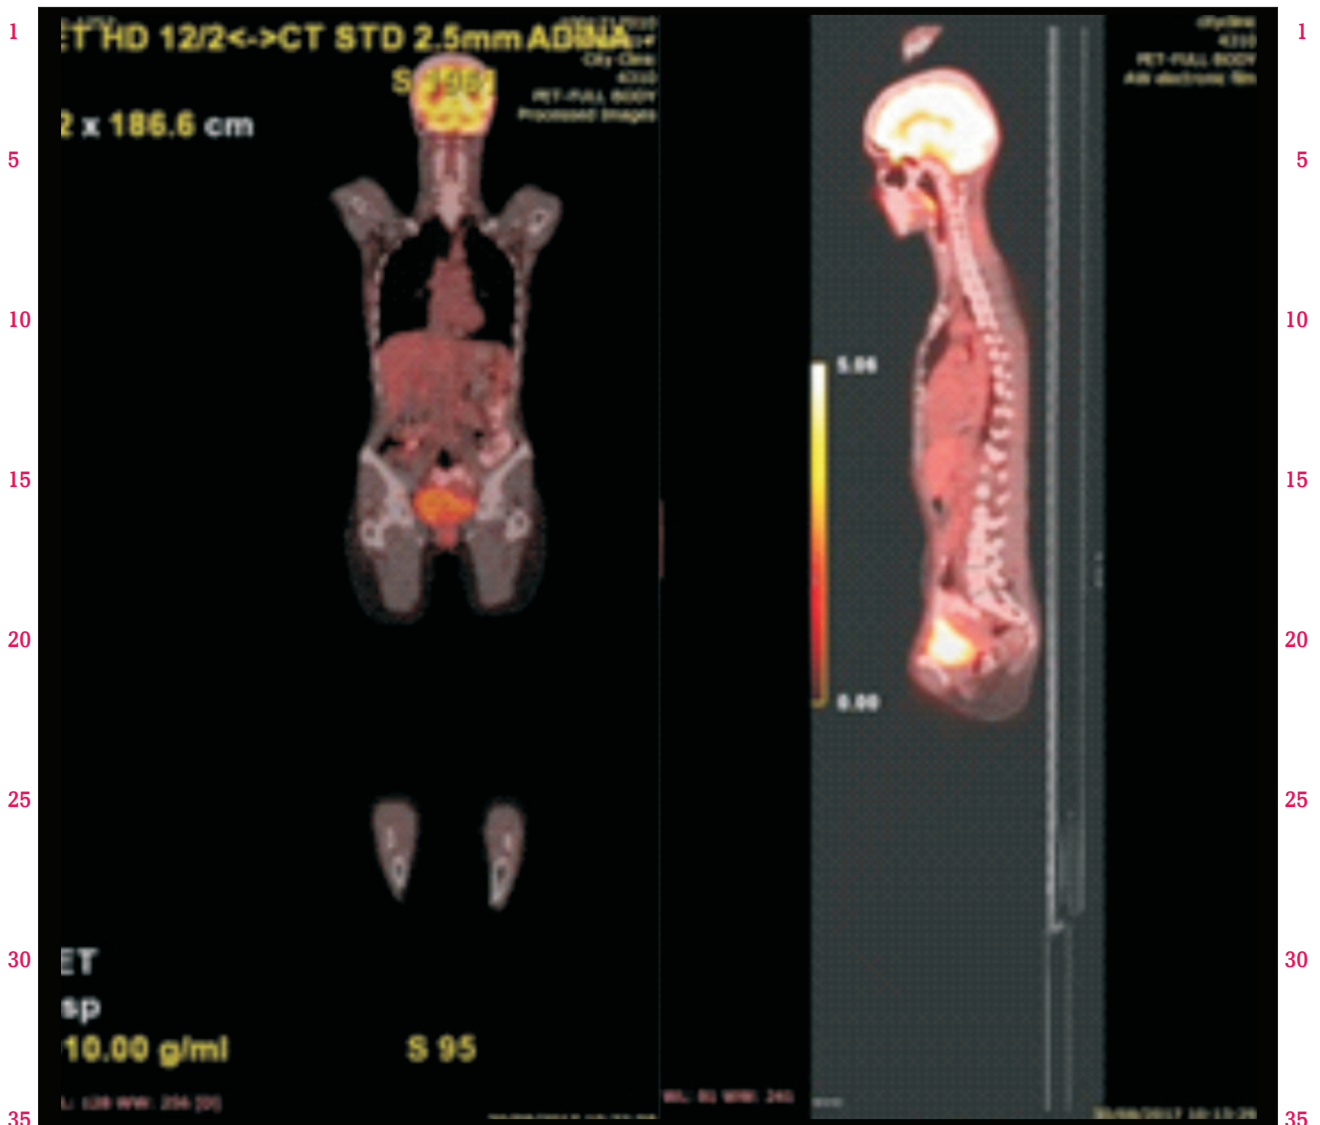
Postoperative PET/CT.
